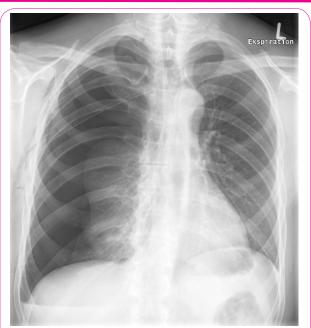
Plain chest x-ray with enclosed chest tube after stopping suction, unfolding a relapsed pneumothorax.
